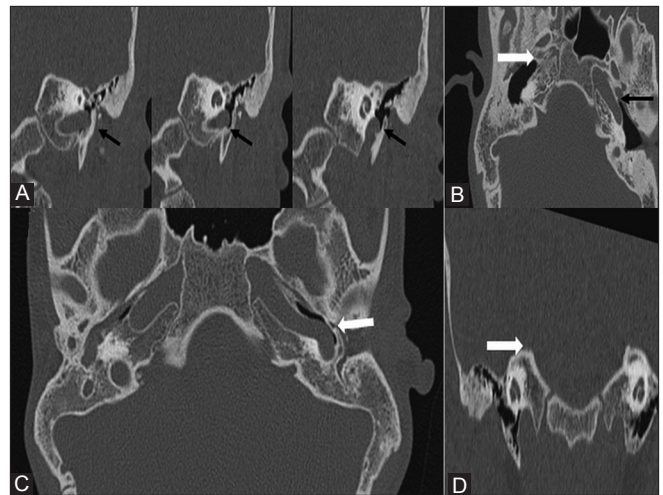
(A-D): Vascular anomalies. (A) Serial coronal HRCT sections shows aberrant course of left internal carotid artery in the middle ear (black arrows). (B) Axial section of same patient shows similar finding (arrow). (C) Axial HRCT section shows absent carotid canal on right side (white arrow). Note the normal carotid canal on left side (black arrow). (D) Coronal HRCT section shows high riding jugular bulb on right side (arrow)
